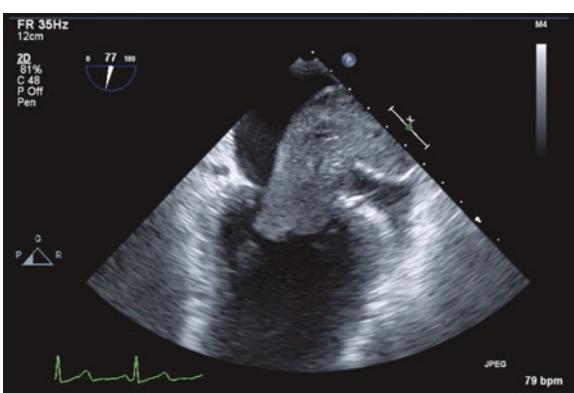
Picture obtained during intraoperative transesophageal examination. Mid-esophageal, two chamber view.
